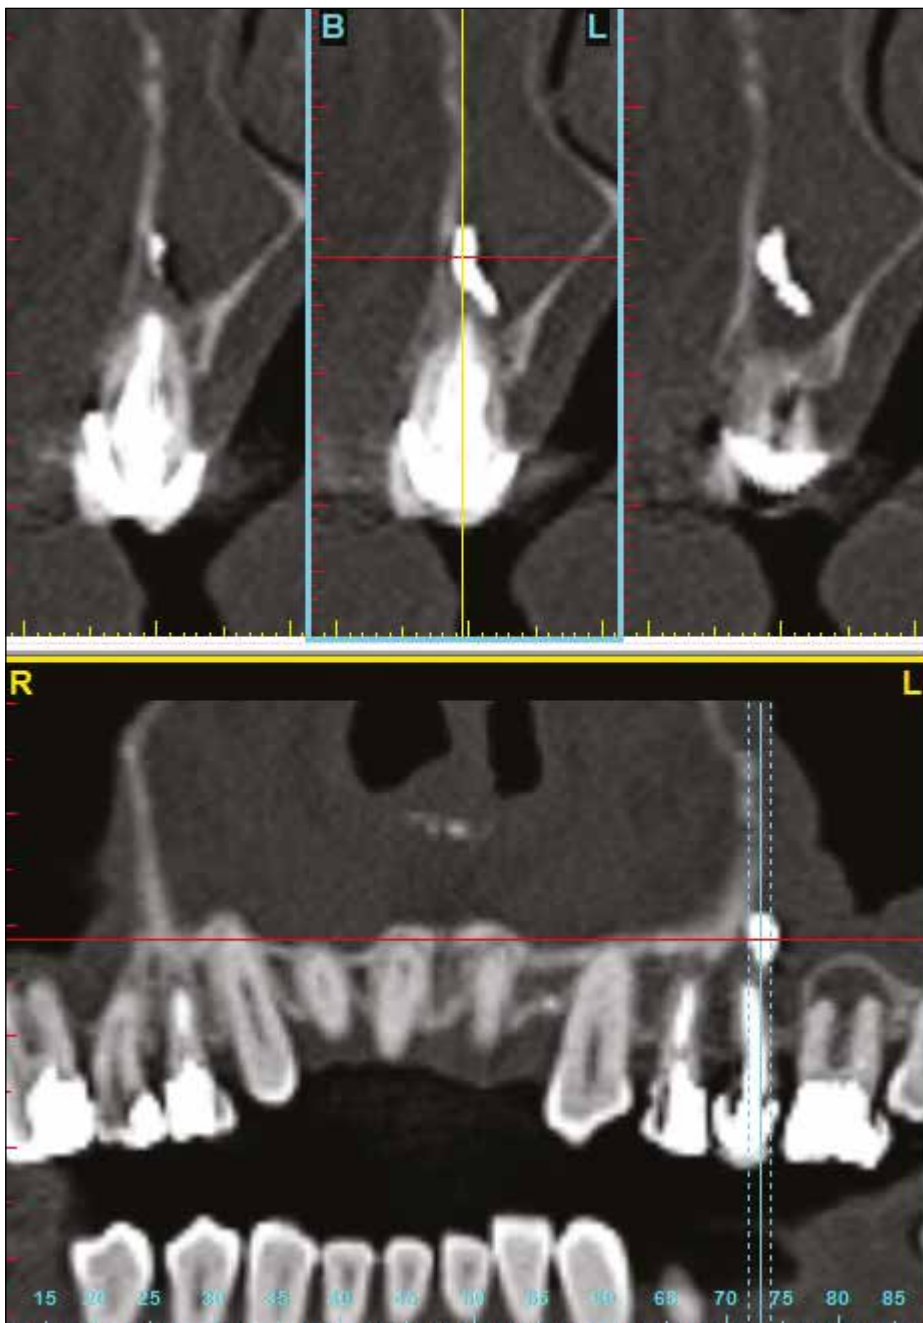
Fragment of computed tomography of the upper jaw of the 52-year-old female patient L., case record No.203. Filling material in the left maxillary sinus.
